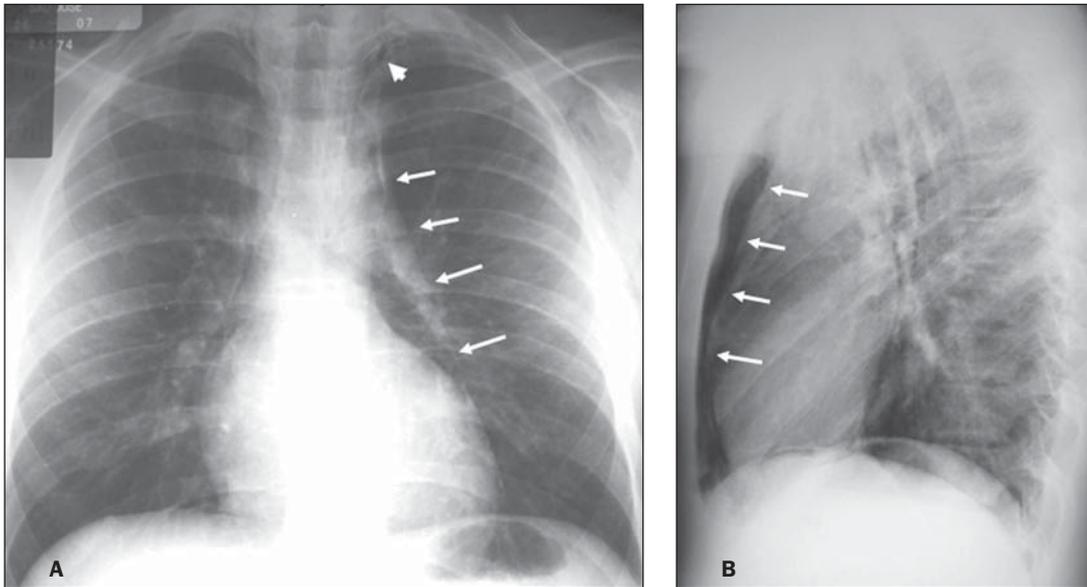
Chest radiography, posteroanterior view (A) and lateral view (B) demonstrating the presence of pneumomediastinum (arrows), pneumothorax at left (arrow head) and soft tissue emphysema. The presence of air dissecting the anterior mediastinum is better demonstrated by the lateral view (arrows).
